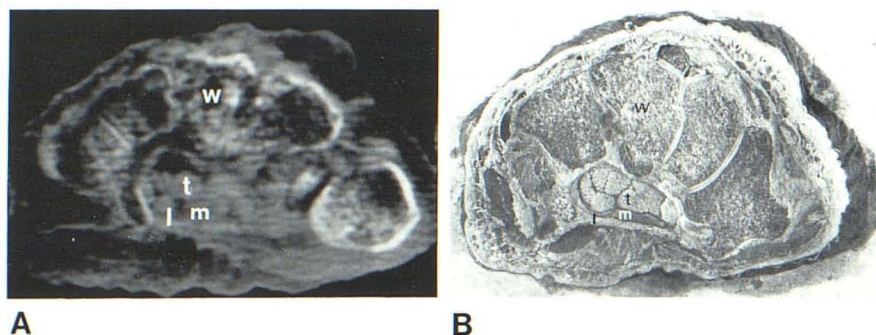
Comparison of CT section (A) and gross morphology (B) of carpal tunnel. w = wrist bones, t = flexor tendons, l = carpal ligament, m = median nerve.
